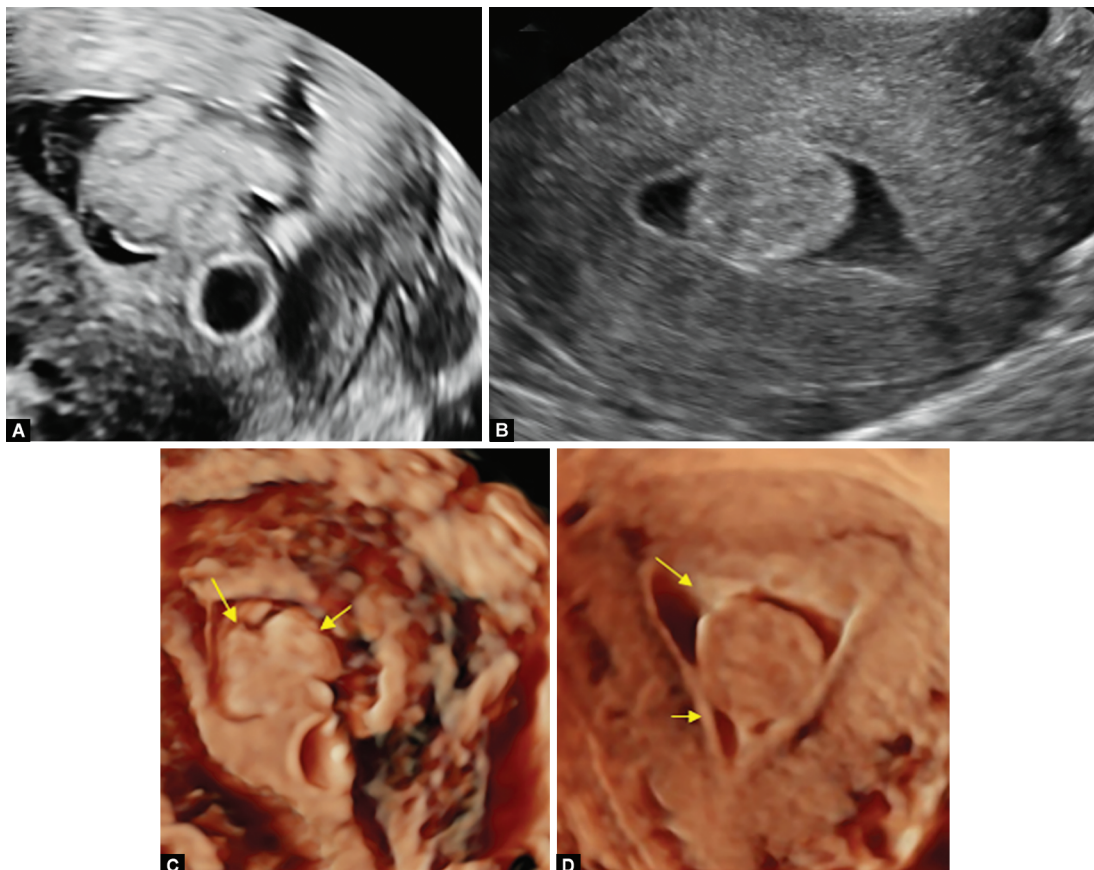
to D: 3D Ultrasonography: (A) Different dimensions and location of leiomyoma. Isthmic cervical location FIGO; type 6; (B) Hugh myoma—same location; (C) Hugh intramural myoma FIGO type 5; (D) Specific location of isthmic cervical myoma
